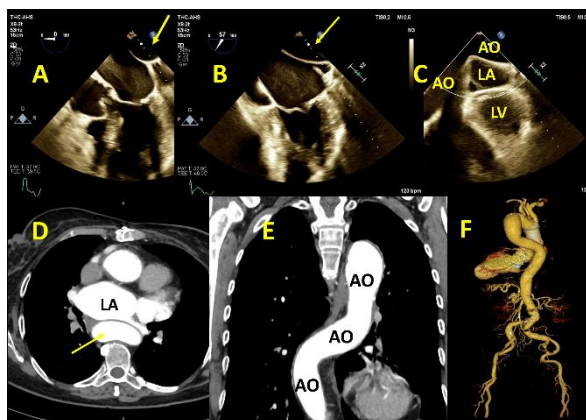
(A) Transesophageal echocardiography showed unusual closeness between the descending aorta and left atrium in the mid-esophageal 0° view and (B) in the 57° view. (C) In addition, transesophageal echocardiography revealed that the descending aorta crossed the midline, appearing as a tubular space posterior to the left atrium, with a compressive effect on it. (D) Axial and (E) coronal sections of the descending aorta on computed tomography angiography demonstrated its crossing of the midline. (F) Reconstructed 3D computed tomography angiography of the descending aorta showed severe tortuosity.
